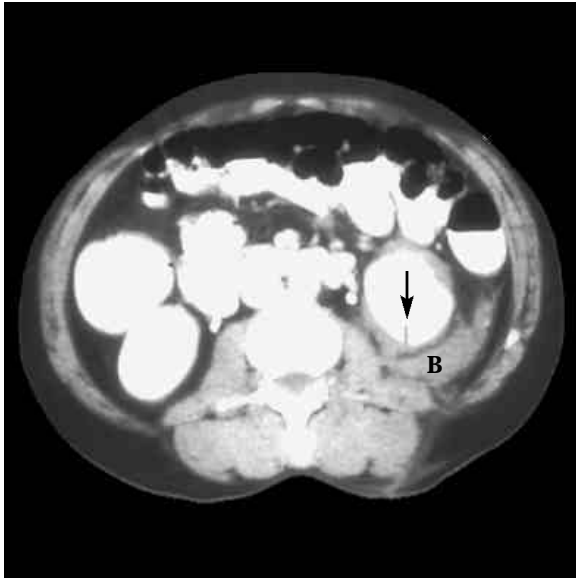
KNIFE WOUND TO KIDNEY CT image. The arrow indicates the location where the left kidney has been damaged by a knife. Note the bleeding (B) around the kidney.
